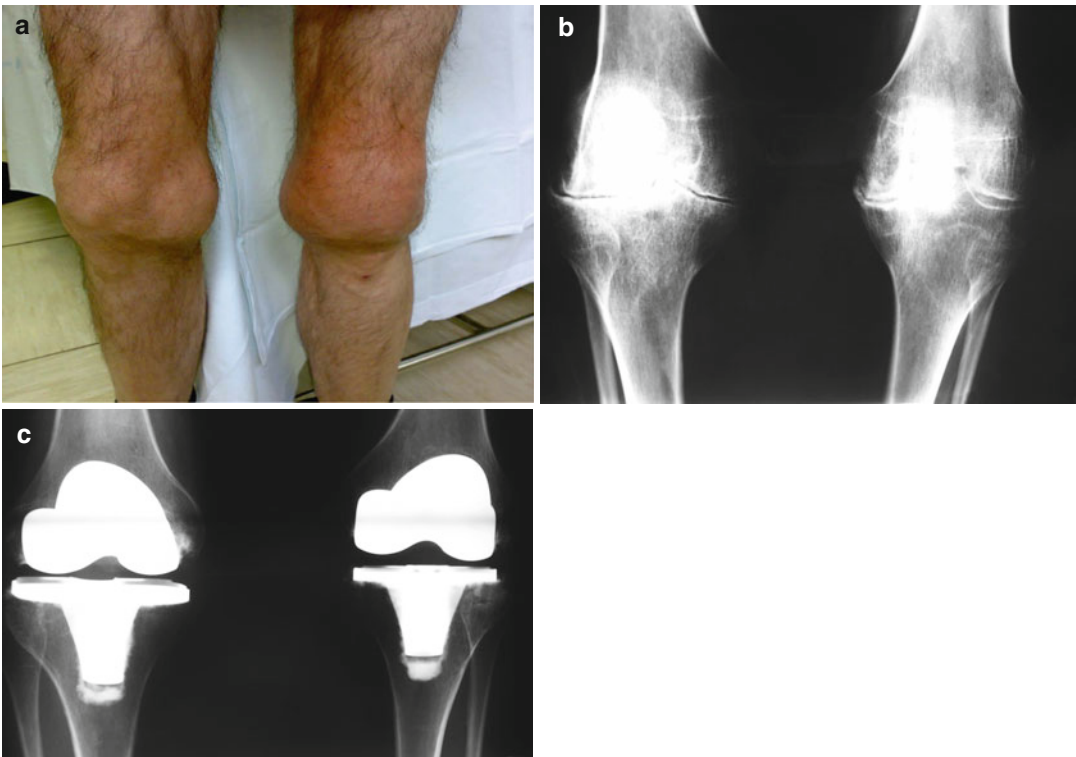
Clinical appearance of severe hemophilic arthropathy in both knees (a) and the radiographic images confirming the joint disease (b). A bilateral total knee replacement was performed in two stages, with a satisfactory result (c)
